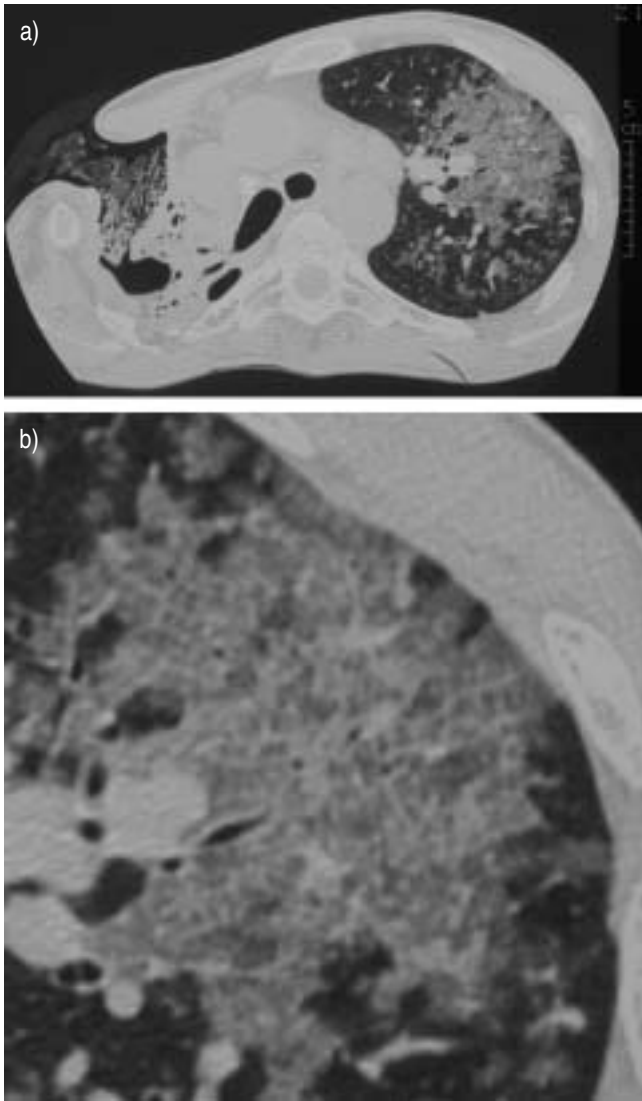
Computed tomography of a) the chest and b) the left hemithorax.
